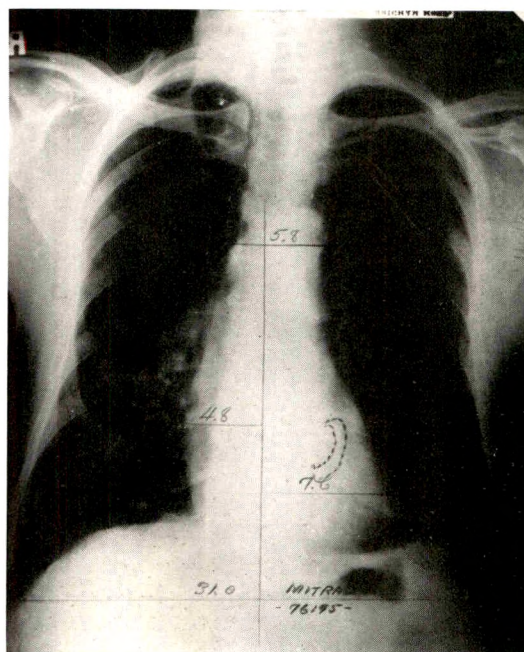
Calcification in the mitral valve (?annulus fibrosus) (Case xxiv). Seven-foot films, valve outlined from roentgenoscopic tracings.
